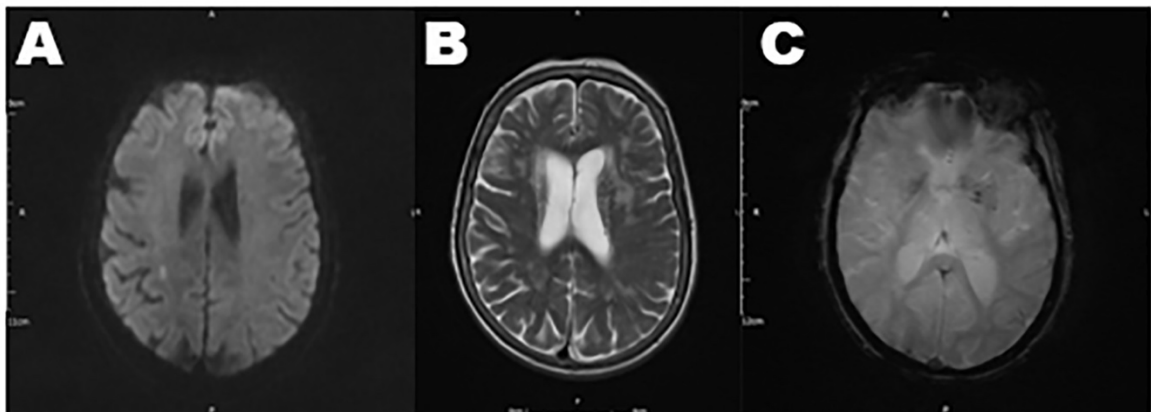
An MRI brain of a poorly controlled hypertensive patient showing (A) Area of restricted diffusion in the left parietal and temporal lobes, (B) Hyperintense T2 signal change, and (C) Severe left internal carotid artery stenosis.
